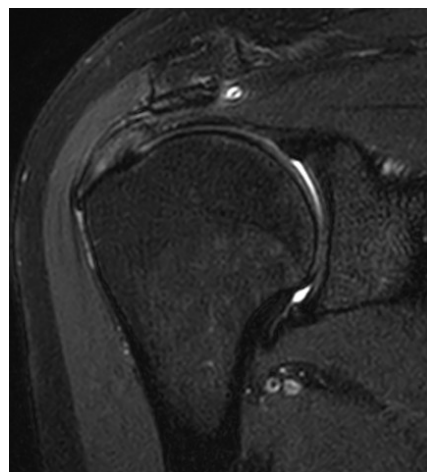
Oblique coronal fat-suppressed T2-weighted MRI scan. Abnormal high signal and focal swelling of the supraspinatus tendon. Provided by the authors.
